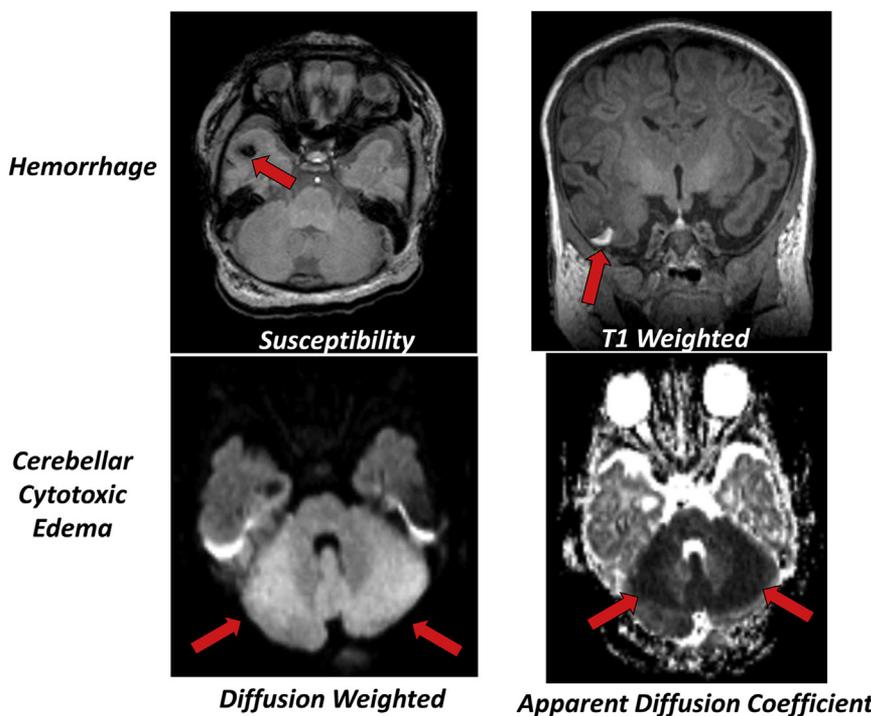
Examples are shown of two brain lesions that led to the decision to postpone the operation. The top two images are an example of hemorrhage from a patient with hypoplastic left heart syndrome: (Left) an axial view that used susceptibility imaging, and (Right) a coronal view that used T1-weighted imaging (red arrows point to the hemorrhage). The bottom 2 axial images are examples from a patient with cerebellar cytotoxic edema using (Left) diffusion-weighted and (Right) apparent diffusion coefficient imaging (red arrows point to the lesion).
